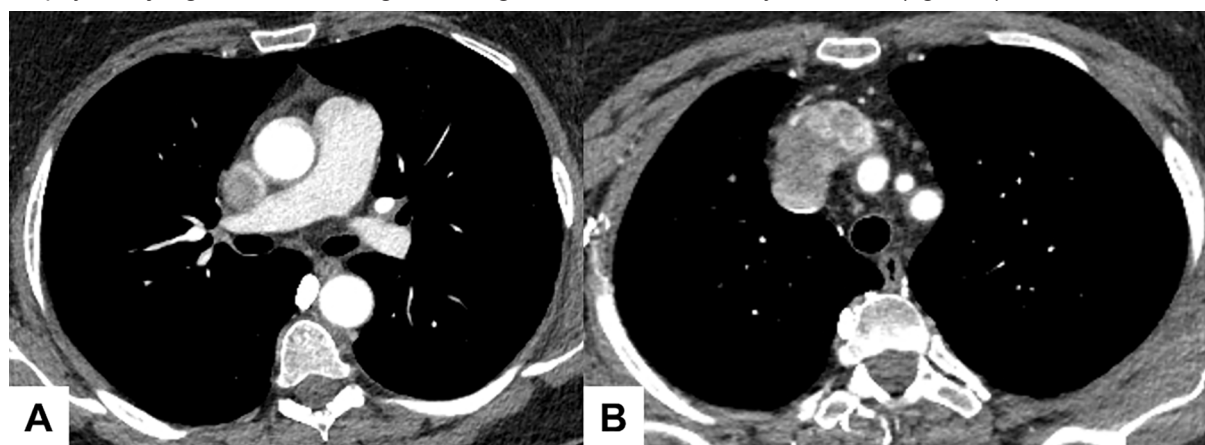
Contrast-enhanced computed tomography reveals a hypervascular intraluminal mass occupying the superior vena cava and brachiocephalic vein. (A) The contrast-enhanced computed tomography shows a hyper vascular intraluminal mass within the superior vena cava. (B) An axial computed tomography image demonstrates tumor extension into the brachiocephalic vein.
